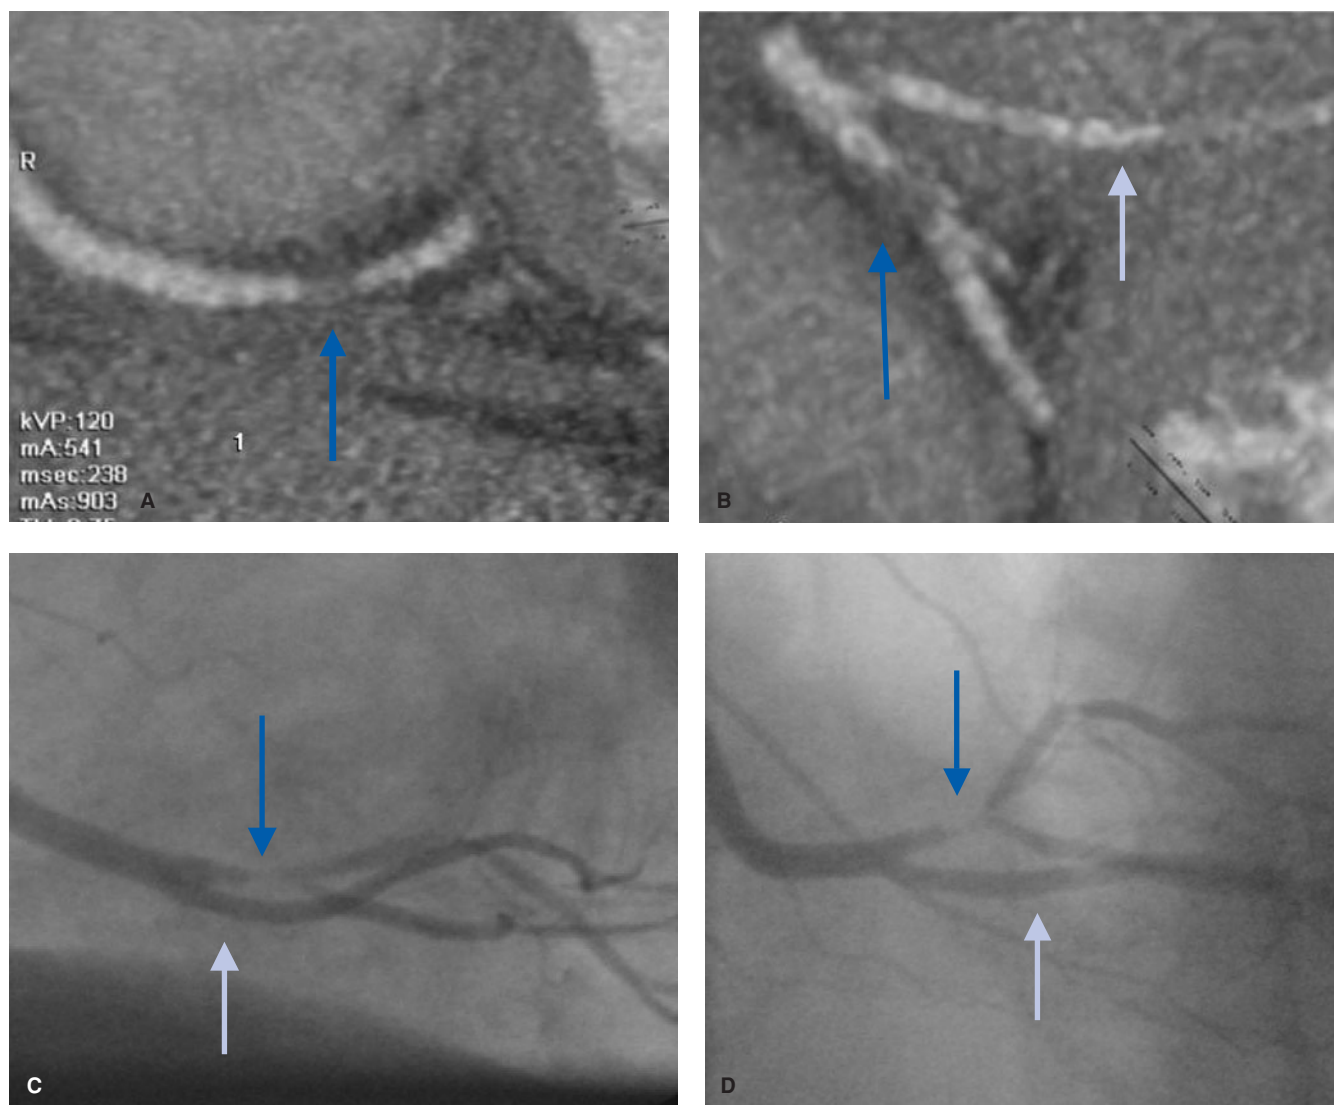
Ongoing RCA greater than 50% stenosis diagnosed by coronary CTA and confirmed by conventional angiography. Double oblique maximum-intensity projection images (4 mm thick) through ongoing RCA at 90-degree angles (A, B) demonstrate a segment of noncalcified plaque with nonvisualization of lumen (*line arrow*). The PIV is also partially demonstrated (*white arrow*). Finding is confirmed by LAO (C) and anteroposterior-cranial (D) projection still images via conventional angiogram (*blue arrow*). The PIV is also seen (*white arrow*).
